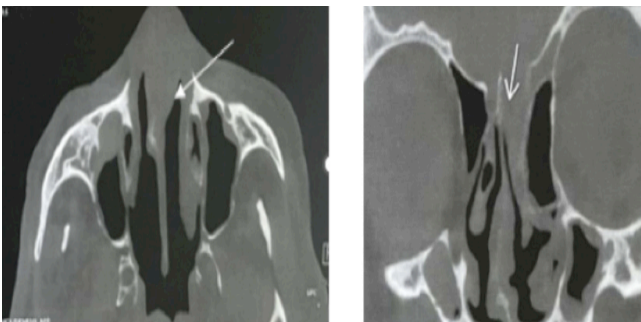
Axial and coronal CT scans of the facial bones showing lysis of the roof of the left ethmoid sinus associated with thickening and bulging of the nasal septum.
